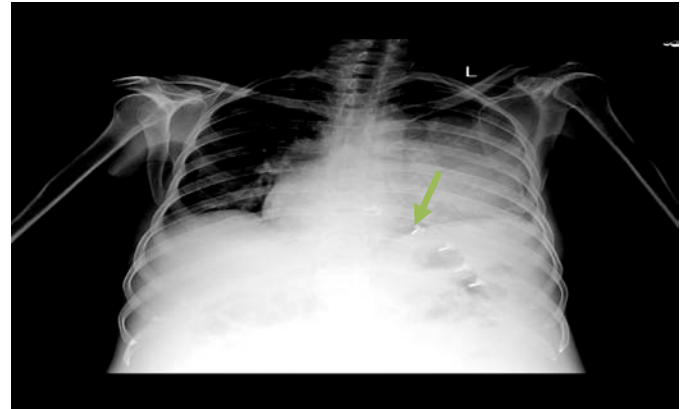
1 Frontal chest radiograph showed widening of mediastinum.
